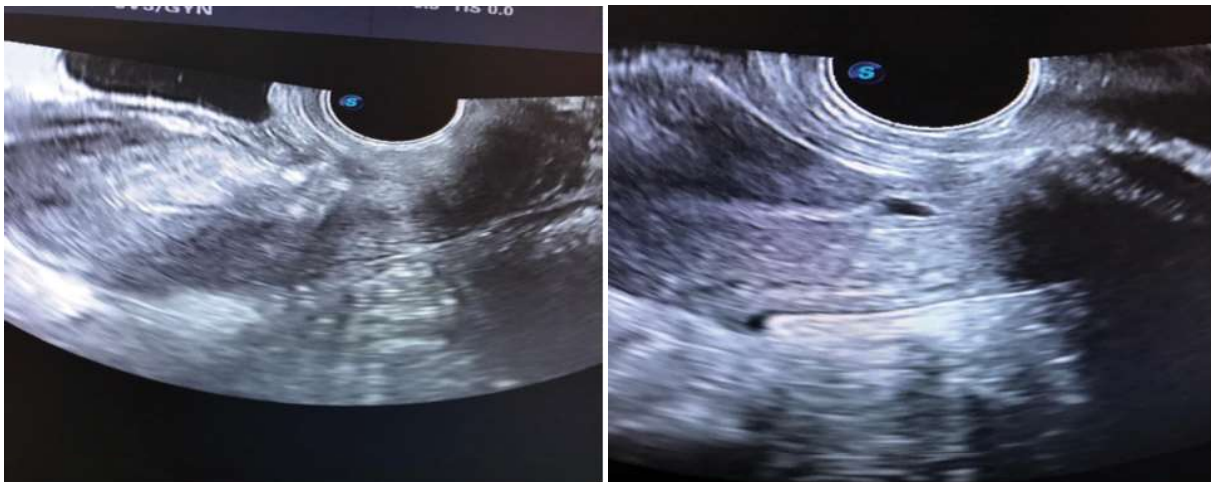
the ultrasound evaluation pf the scar defect before and after ithmoplasty
